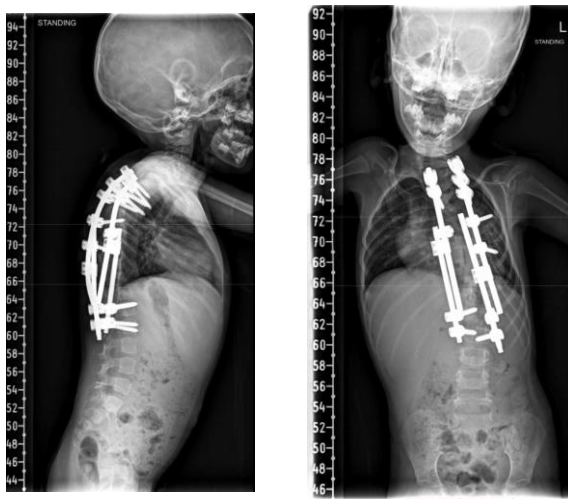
Clinical postoperative AP and lateral radiographs from May 2025 demonstrate a major coronal curve correction to 33° with improved overall alignment. The instrumentation from T2 to L2 remains intact, showing satisfactory placement and no evidence of mechanical failure.
